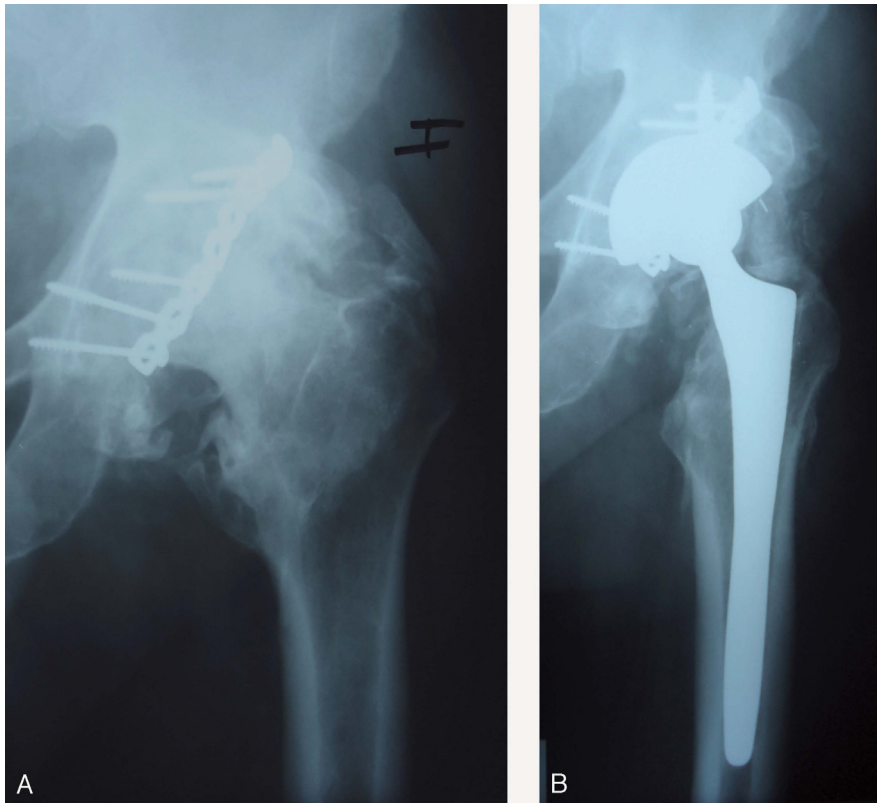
63-year-old male. A) Anterior-posterior x-ray of the hip. Coxarthrosis at 3 years after open reduction and synthesis of wall and posterior column acetabular fracture. Heterotopic ossifications grade III. B) Anterior-posterior x-ray of hip, followed for 6 years after cementless total hip arthroplasty. Heterotopic ossifications grade III. Fair results.
